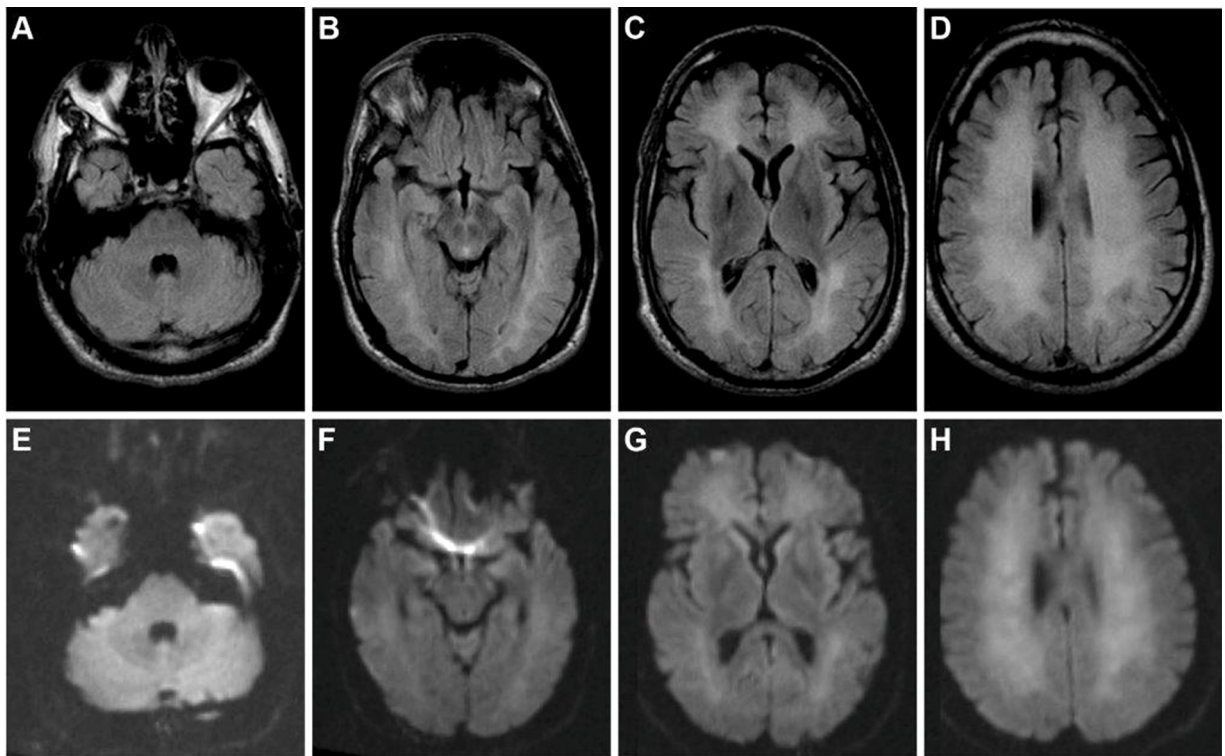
Diffuse white matter alterations. Example of typical imaging findings: in FLAIR imaging (Fluid attenuated inversion recovery, upper row) increased signal intensity of the white matter with extensive involvement of the temporal, frontal/parietal and occipital lobe is present. The cortex, basal ganglia, brain stem, and cerebellum are not involved. After contrast injection pathologic uptake is not present (not shown). Diffusion weighted imaging (DWI, lower row) shows high signal intensity at a b -value of 1000 of the white matter as on corresponding apparent diffusion coefficient (ADC, not shown) maps
